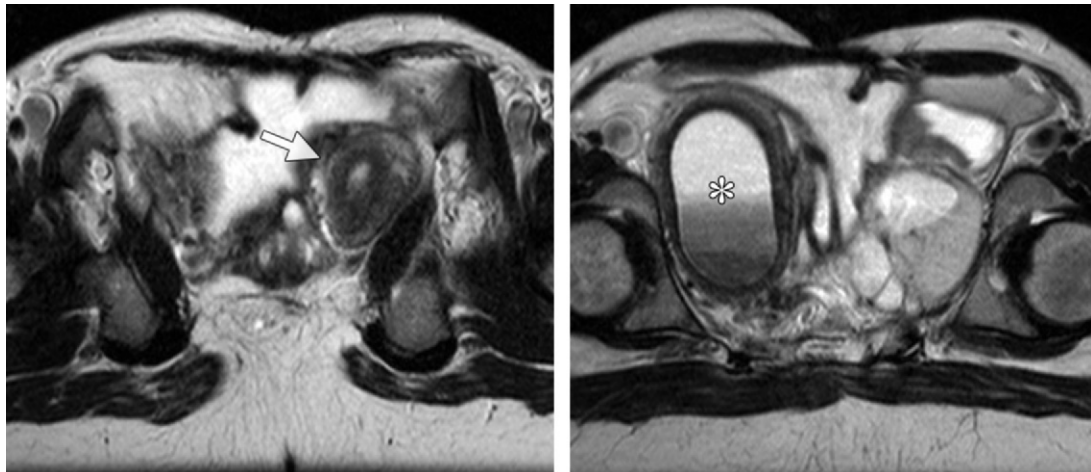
Unicornuate uterus with an obstructed noncommunicating rudimentary horn. Axial T2-weighted MR images show a normal-appearing left unicornuate uterus (arrow in a) and an obstructed noncommunicating right rudimentary horn with layering debris (* in b).
